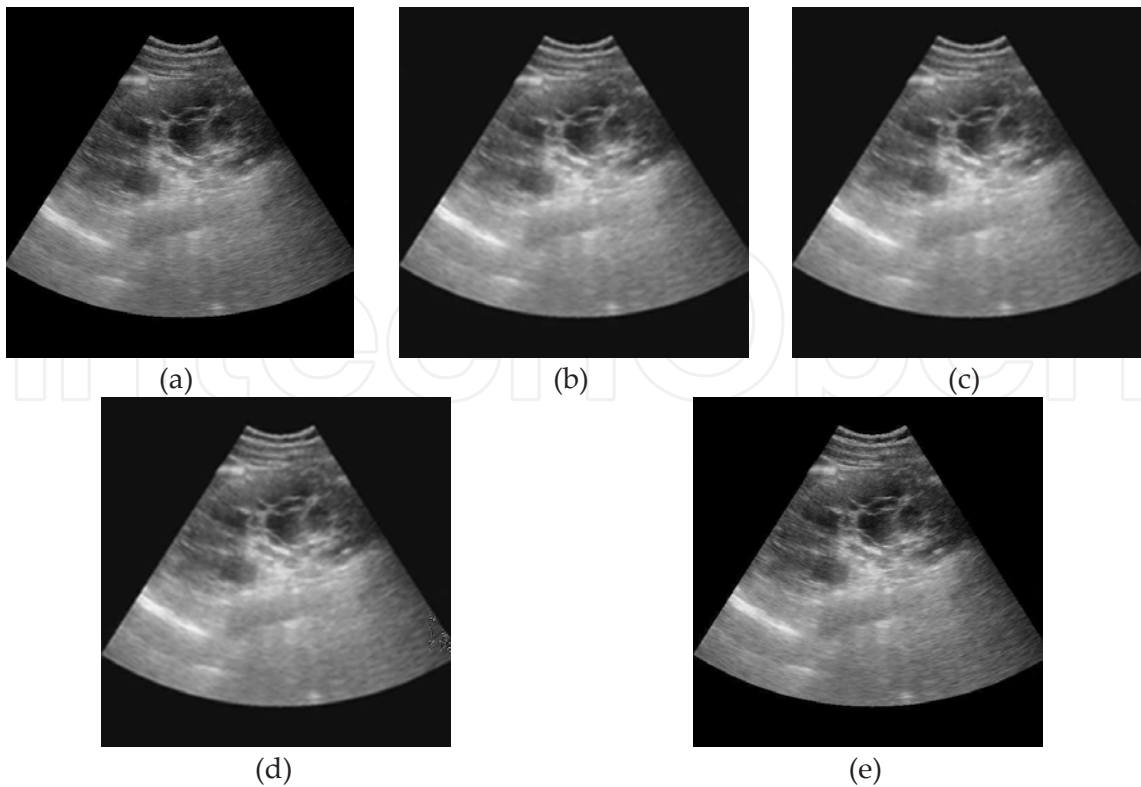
a) Original ultrasound image (b) Despeckled image using cycle spinning based CT using ST method. (c) Despeckled image using cycle spinning based CT using HT method. (d) Despeckled image using cycle spinning based CT using SST method. (e) Despeckled image using direct CT method.
